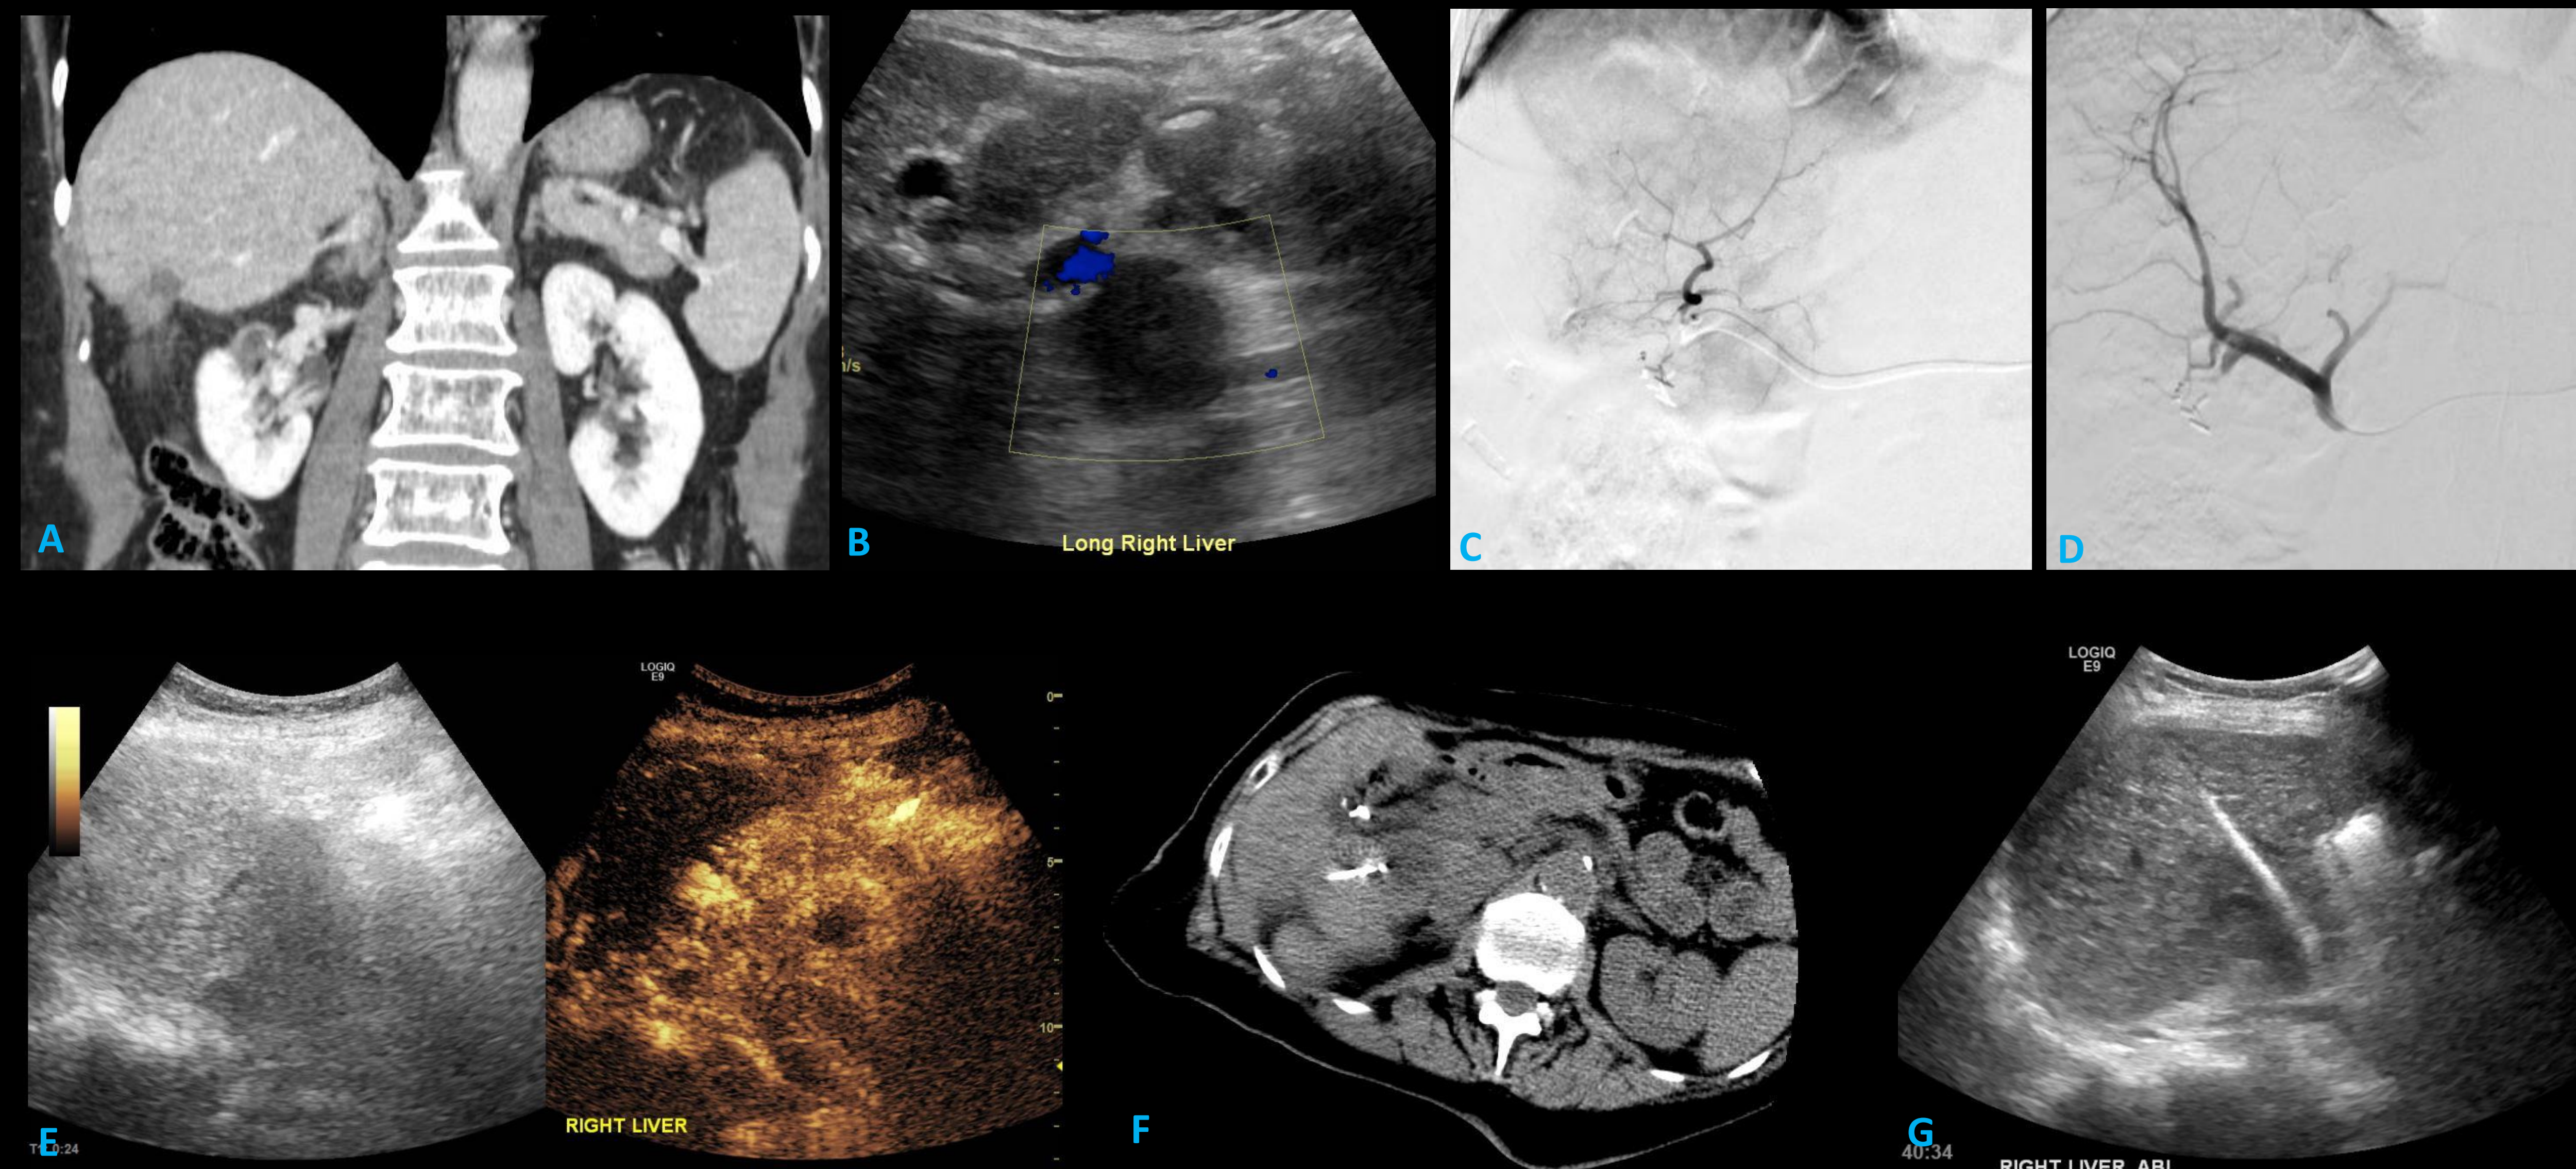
(A) Coronal CT shows hypoattenuating lesion with desmoplastic reaction in inferior right hepatic lobe. (B) Corresponding ultrasound appearance (C) Right hepatic artery DSA prior to particle chemoembolization, showing subtle tumor vascularity and opacification. (D) Post-chemoembolization DSA performed after microcatheter is withdrawn proximally. (E) Greyscale and contrast-enhanced ultrasound of the treated lesion. Note the difficulty in discerning the lesion, which becomes much more conspicuous after contrast. Echogenic areas indicate residual viable tumor, while hypoechoic center represents necrosis. (F) planning CT to identify surrounding structures. Note close proximity to bowel and IVC. (G) Successful microwave ablation of the lesion.
